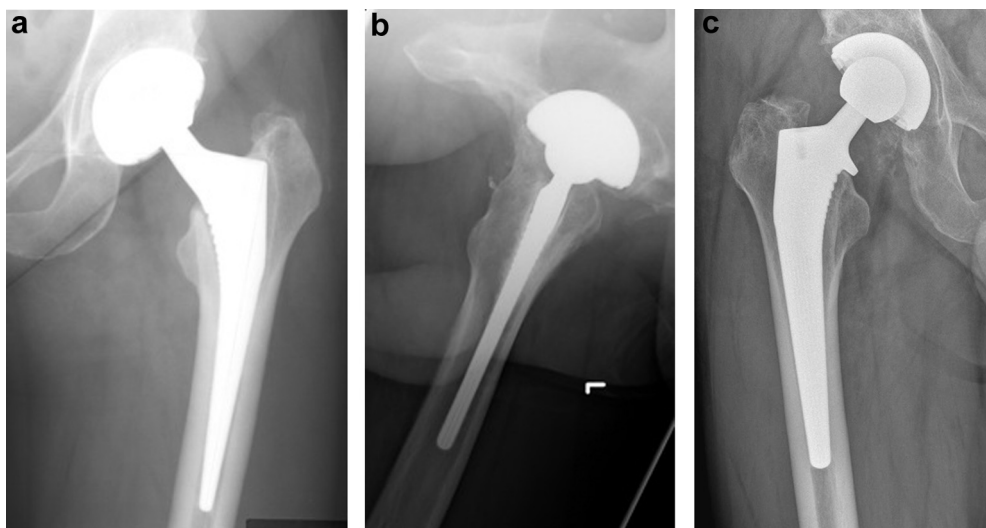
Plain radiograph comparison of a KS collarless (a and b) and KA collared (c) corail cementless femoral component, both at ten years after implantation, and both in patients with no pain. Note in 1a and 1b the radiolucent lines in Gruen zones 1,7,8 and 14.
